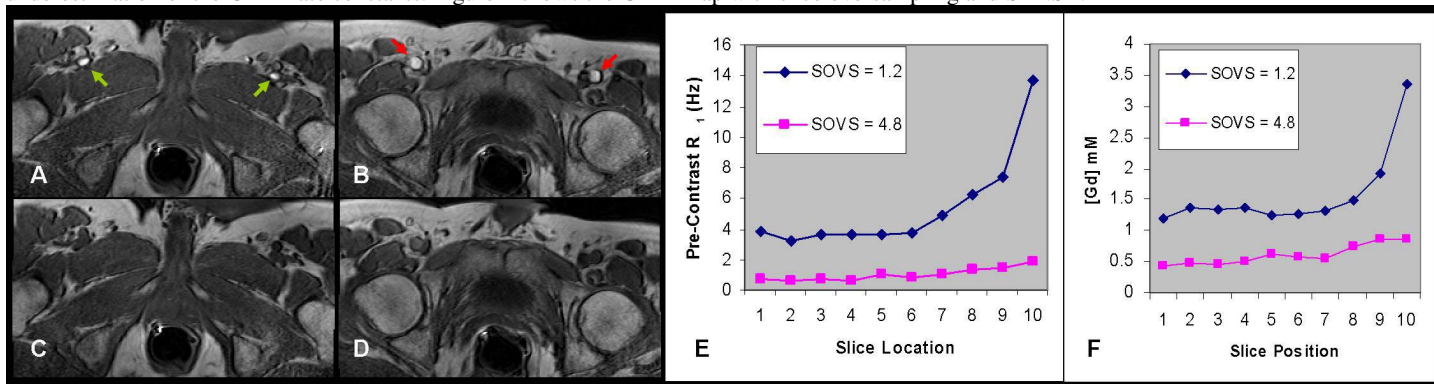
Blood inflow during DCE-MRI results in bright veins in inferior slices (A, green arrows) and bright arteries in superior slices (B, red arrows) with normal 1.2X slice oversampling but little effect with higher 4.8X slice oversampling. The reduced error with higher oversampling is shown in the precontrast R_1 rates (E) and calculated Gd concentration at the end of DCE-MRI study (F) as a function of slice position
